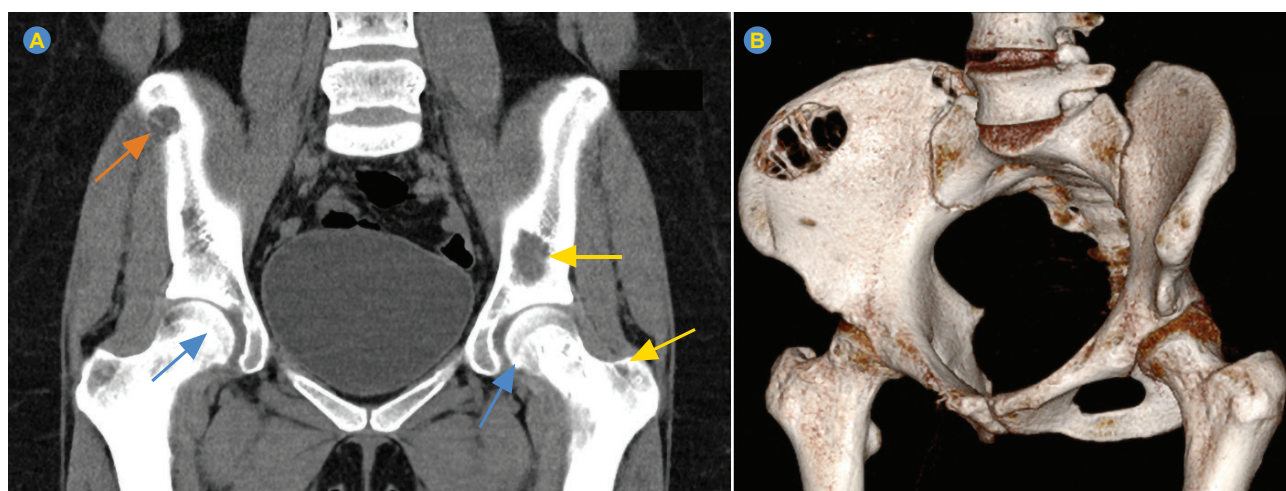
(A) Hip CT (yellow arrows – lytic bone lesions on iliac bone and femurs; blue arrows – cortical thinning; orange arrow – soft tissue component) and (B) 3D reconstruction of hip CT images
